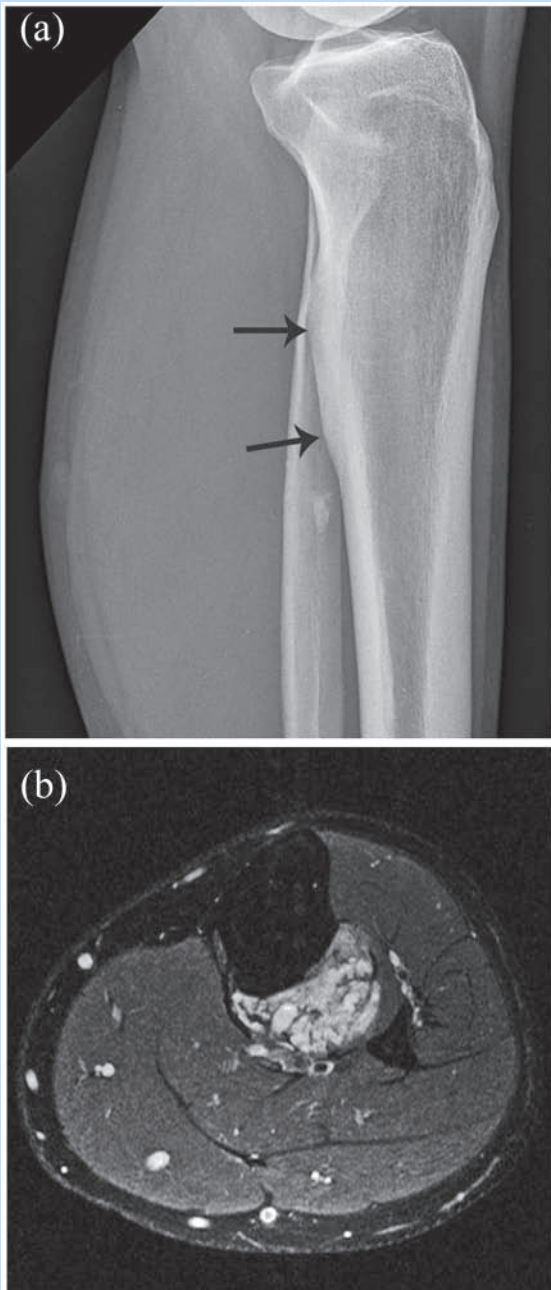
The 31-year-old man with a left proximal calf mass described in Case 1.¹² (a) The lateral radiograph shows bony hyperostosis of the posterior cortex of the left proximal tibia (arrows) and an incidental enchondroma in the fibular shaft. (b) Axial T1 image shows a juxtacortical hemangioma of the left proximal calf.
